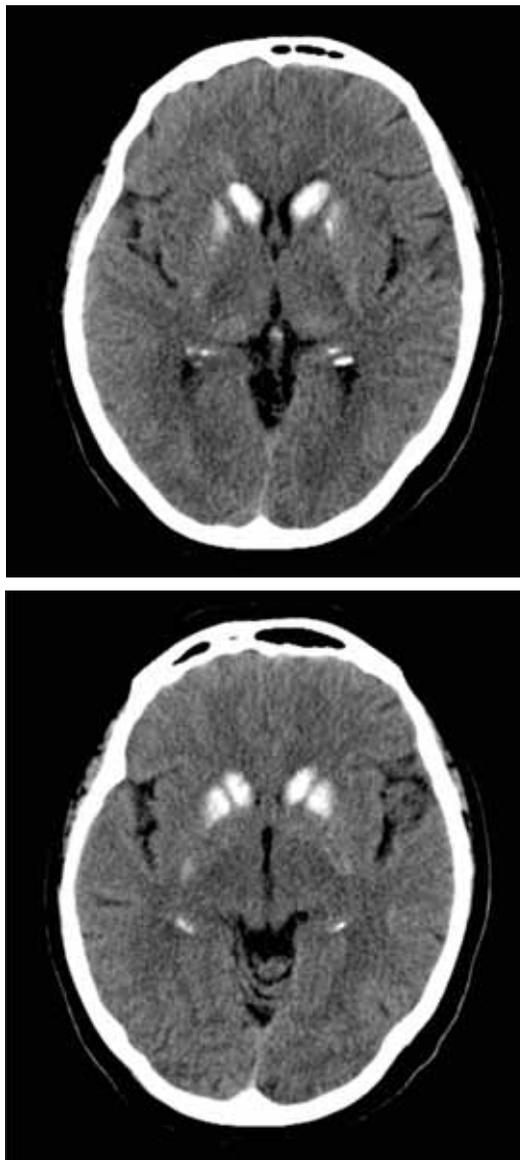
Brain computed tomography revealed severe calcification of basal ganglia
